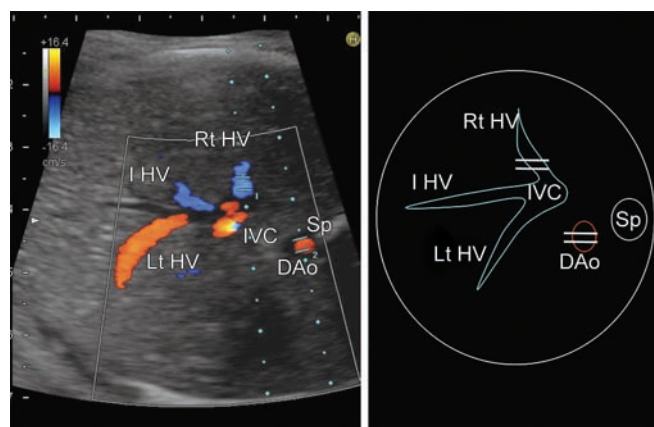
Transverse color Doppler image of the fetal abdomen showing HV draining into the IVC and the DAo anterior to the spine
